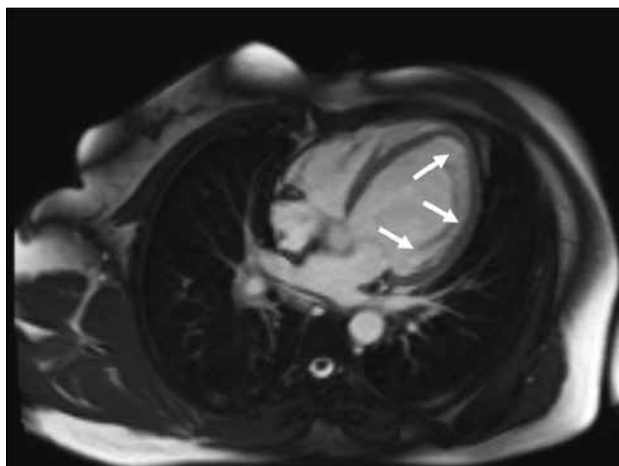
Left ventricular noncompaction. A 59-year-old woman with an ejection fraction of 45%. Images including 4-chamber view cine steady-state free precession (a, b), T2-weighted fast spin echo (c), 4-chamber late gadolinium enhancement (LGE) (d, e), and 2-chamber LGE (f) showing apical, mid and basal ventricular noncompaction.
